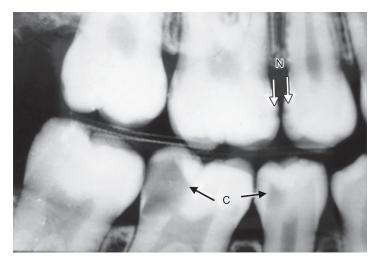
Bitewing radiograph showing proximal caries [C]
